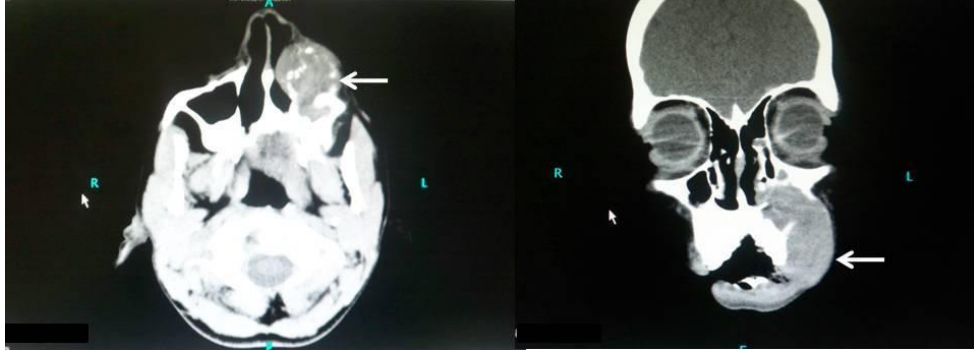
Axial and coronal CT scans showing the size of the lesion.
